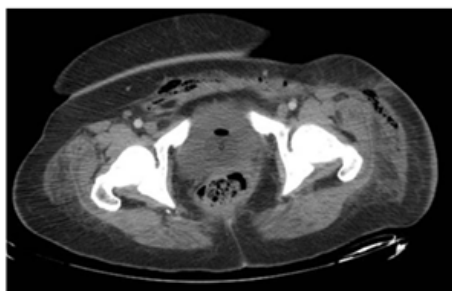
CT scan that reveals the extension through the abdominal wall.
